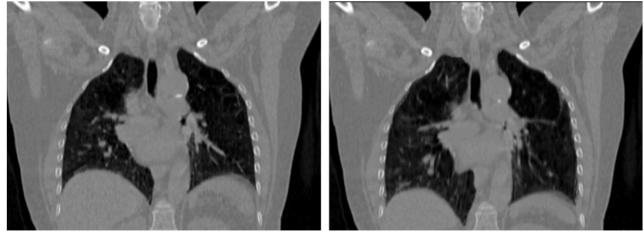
Left: reference CT slice (CT1). Right: end inhale slice of the 4DCT-MRI (using motion MRI1\_1).
